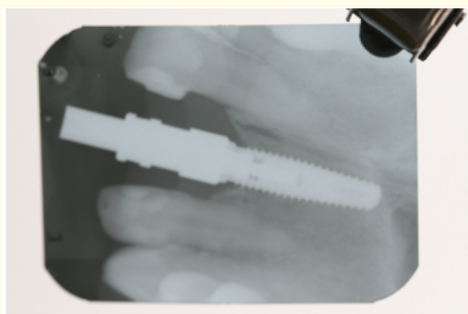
Periapical radiography, proving adaptation of the transference to the implant head.
